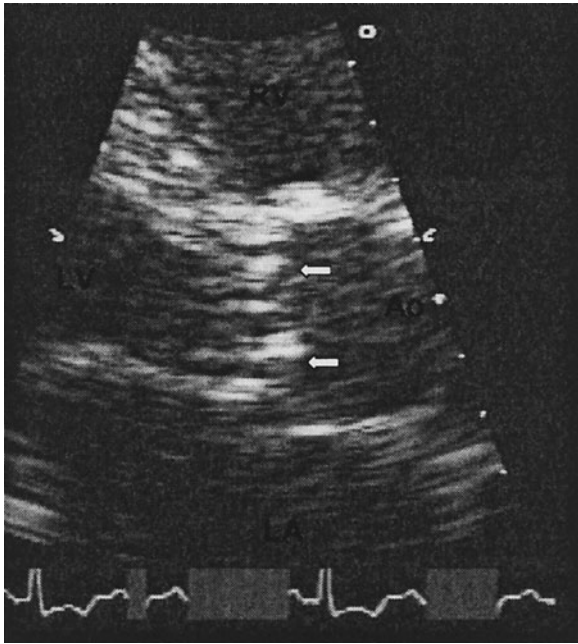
Two-dimensional echocardiography of a patient with aortic stenosis (AS). The aortic valve (arrows) is heavily calcified (dense nodules). LV = left ventricle; LA = left atrium; Ao = aorta, RV = right ventricle.
